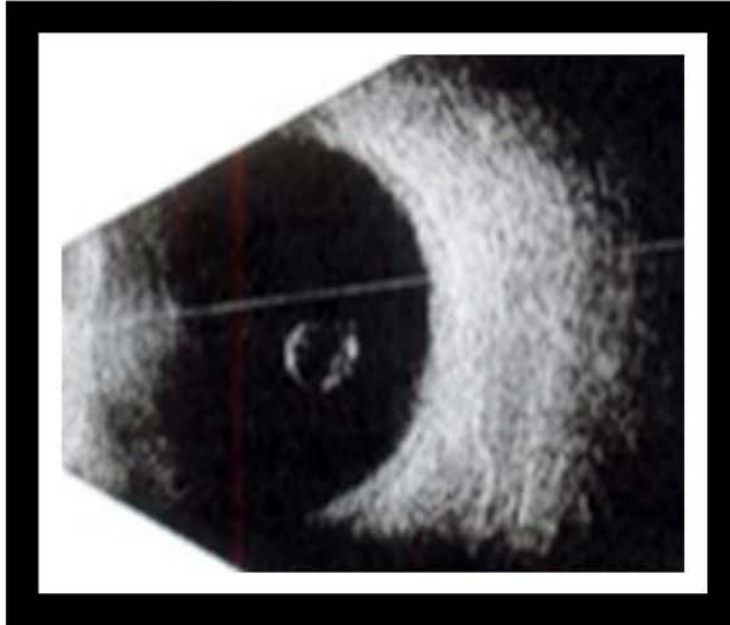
B-scan ultrasonography shows a free-floating hypoechogenic vitreous cyst without attachments.
